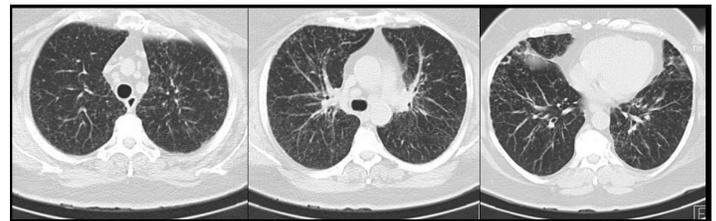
Thoracic high-resolution computed tomography of a patient with talaromycosis who presented dyspnea and productive cough. The images present generalized affection with ground-glass opacities, alveolar occupation, micro and macronodular infiltrates multiple-focus pneumonia and peribronchovascular inflammation
